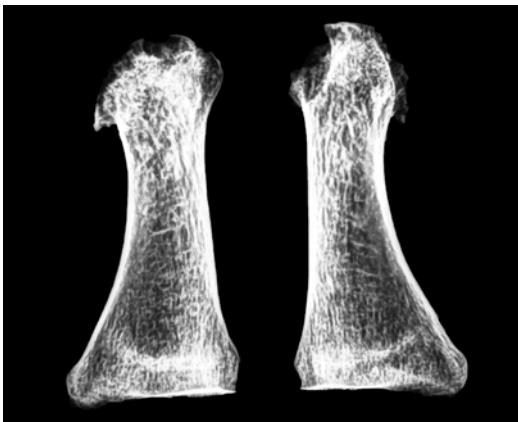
Lateral and antero-posterior projection X-rays of the first metatarsus. The joint profile of the distal epiphysis is irregular, with higher erosion at the dorsal profile
